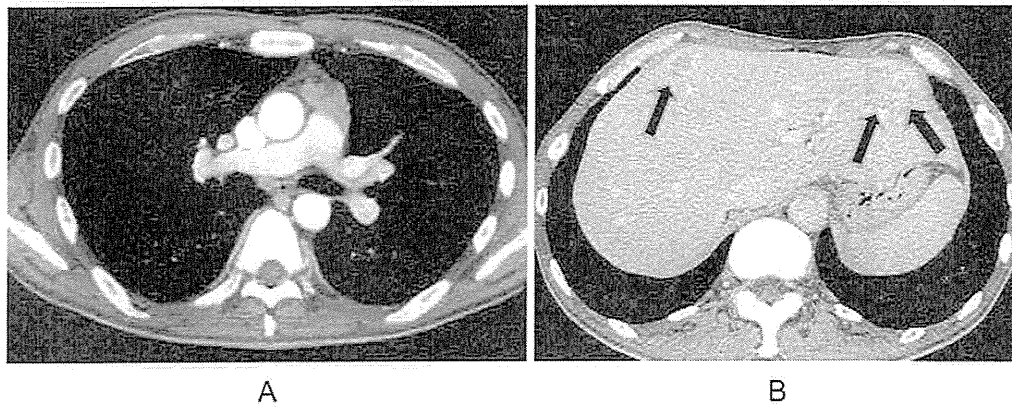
Chest computed tomography showed abnormal masses in the anterior mediastinum (A) and liver (B).
